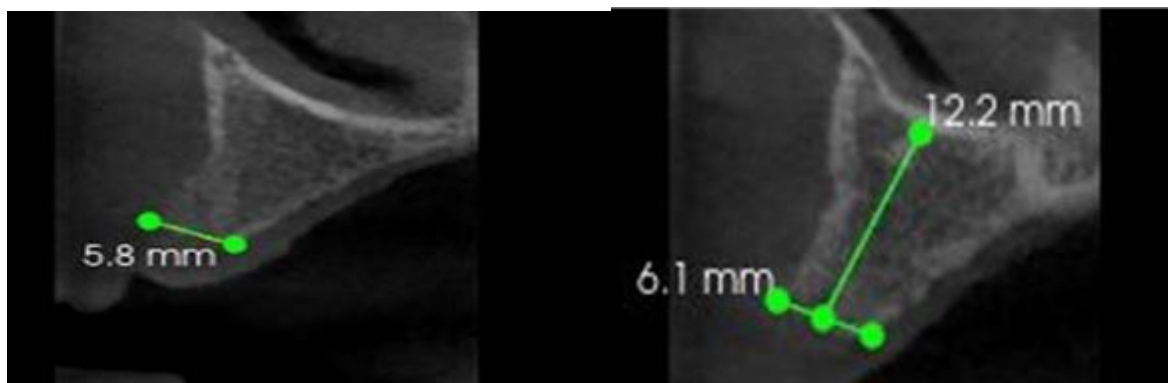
(a)Pre-extraction CBCT
